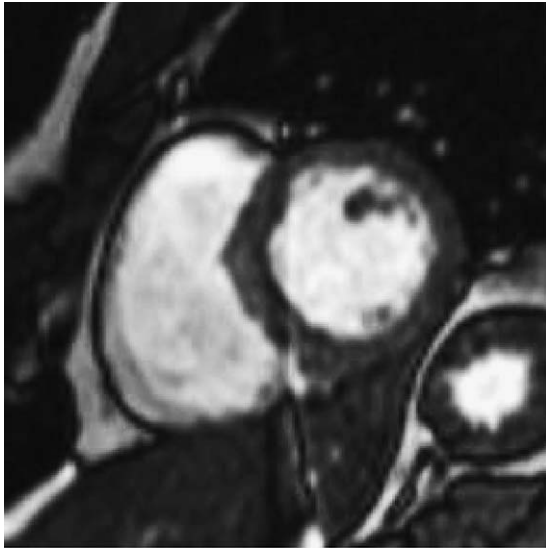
Short-axis MRI slice in diastolic phase.
